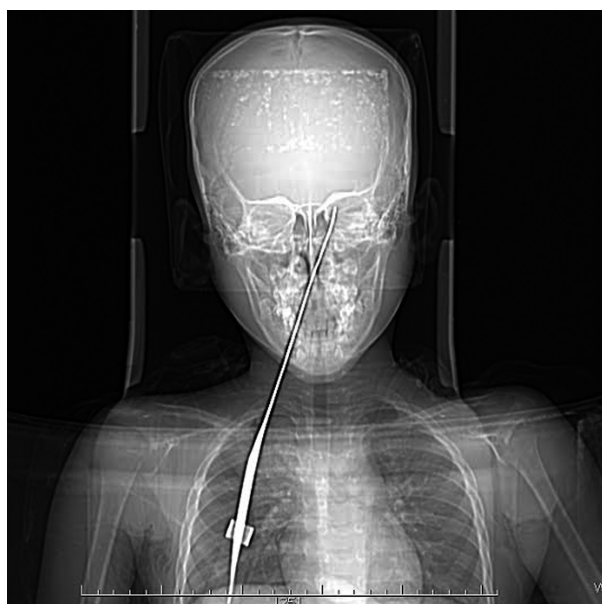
Coronal view of CT scan showing the entry point and the extent of foreign body.
